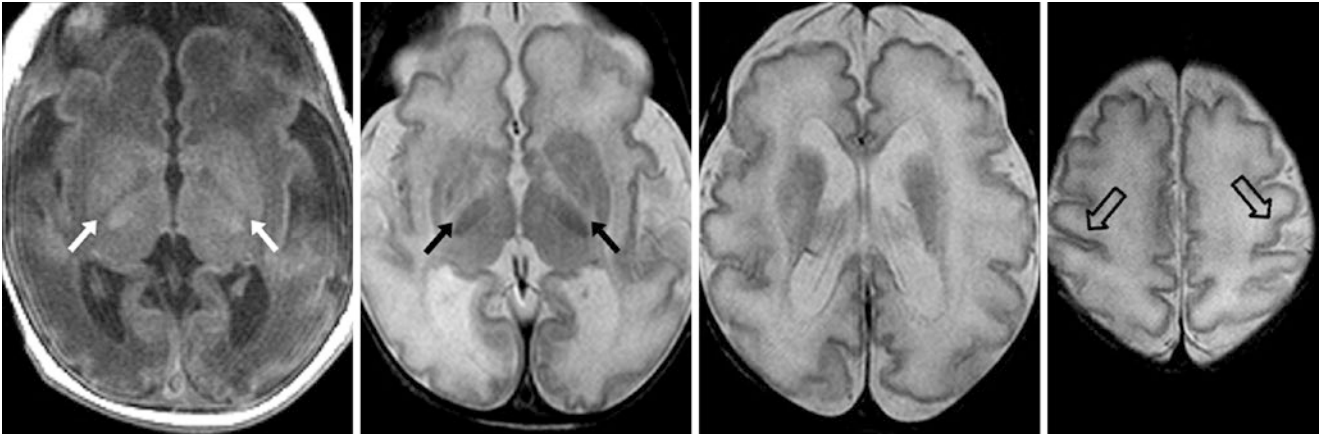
Comparison case of hypomyelination and delayed sulcation. A 4-day-old term neonate with severe hypotonia had a 1.5T MRI that showed a lack of the normal, bright PLICs (*arrows*) on GE T1WI (*left*) and SE T2WI (*left middle*). At higher levels, SE T2WIs demonstrate a lack of the normally dark CSTs within the corona radiata (*right*
